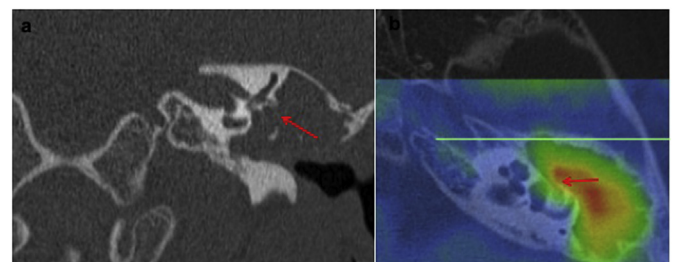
(a) Coronal CT show disease possibly eroding facial nerve canal (confidence score 3) (red arrow). (b) Axial fusion image shows confidently (score 5) disease in the region of the canal. (For interpretation of the references to colour in this figure legend, the reader is referred to the Web version of this article.)
